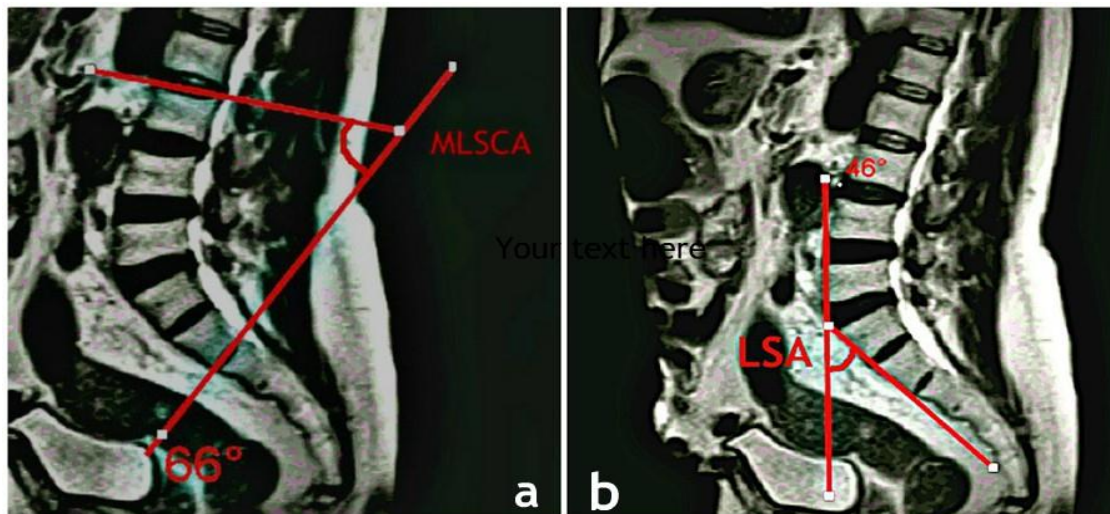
MRI image showing (a): maximum lumbo-sacral curve angle (MLSCA); (b): lumbo-sacral angle (LSA) in the sagittal plane.
